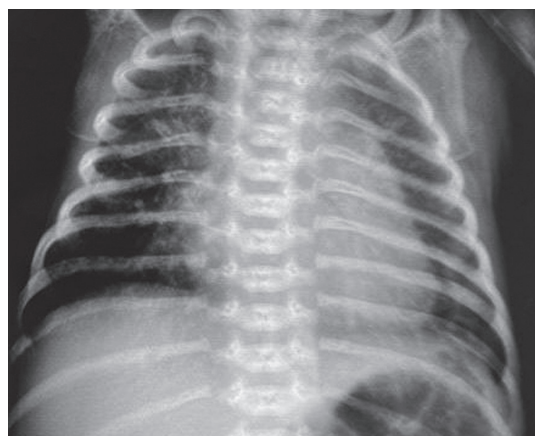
Chest X-ray of newborn with spontaneous breathing
